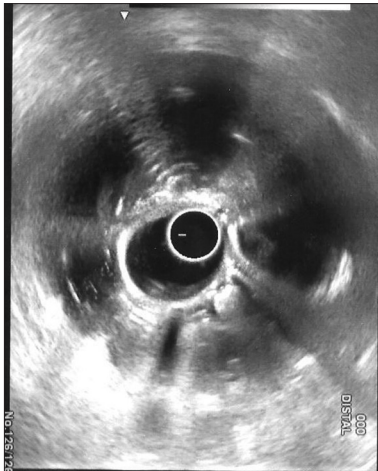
Radial endoscopic ultrasound image showing submucosal anechoic lesions
